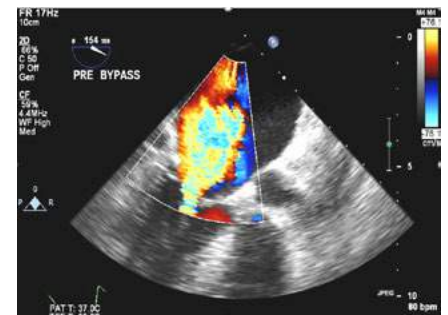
Transoesophageal 2-D echocardiogram with Colour Doppler showing the severe mitral regurgitation into an enlarged left atrium secondary to incomplete closure of the mitral leaflets. In transoesophageal echocardiography, the top of the picture depicts the left atrium due to its close proximity to the oesophagus where the probe lies.
